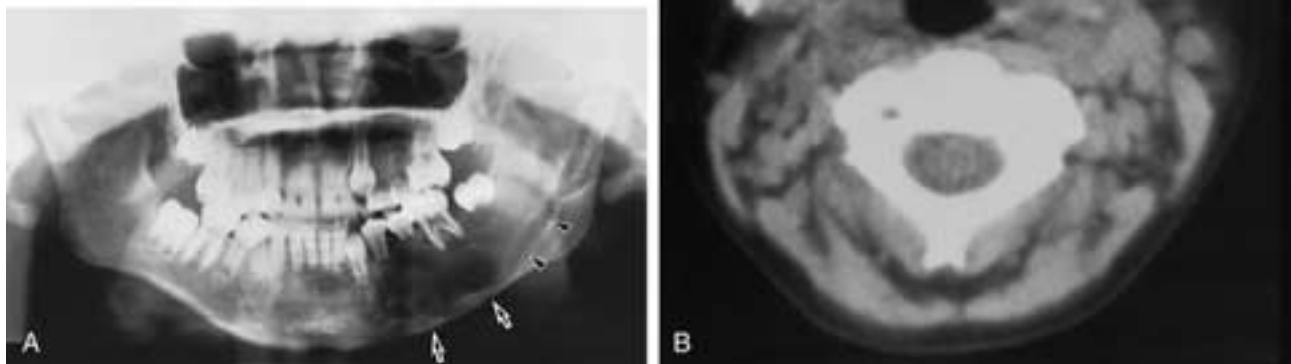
Central hemangioma in the mandible. A, Pantomogram shows a large radiolucent lesion in the mandible (arrows). The inferior alveolar nerve canal has been widened, and its course has been altered (arrowheads). B, Axial CT (soft-tissue window setting) shows a well-defined, slightly expansile lesion (arrow). Note the increased density within the lesion suggesting blood rather than cystic fluid. (Courtesy of Dr. T. Kurabayashi, Dept. of Dental Radiology, Tokyo Medical and Dental University, Tokyo.)
